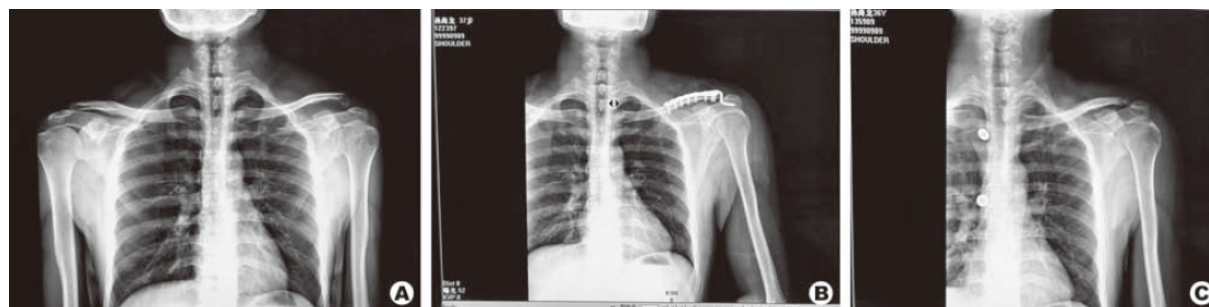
X-ray results of TOSSY type III left acromioclavicular joint dislocation before and after clavicular hook plate combined with coracoclavicular ligament repair
